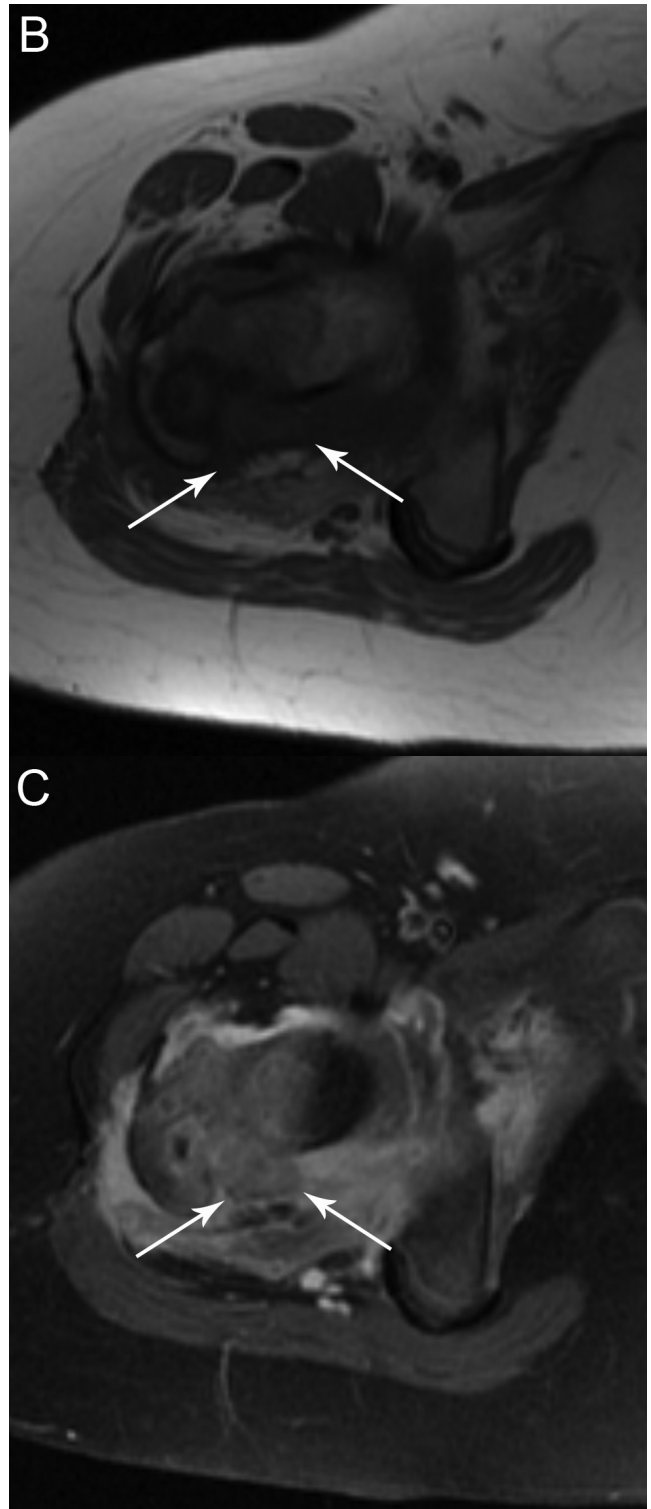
10-year-old girl with recurrence of chondroblastoma. MRI of the right hip. (B) axial T1 (TR 550/TE 513), and (C) axial postgadolinium fat-saturated T1 (TR 500/TE 13) MR images of the right hip. Relatively hypointense T2 and T1 lesion (arrows) in the soft tissues posteromedial to the greater trochanter, with an associated joint effusion and inflammatory changes in the soft tissues and bone.
